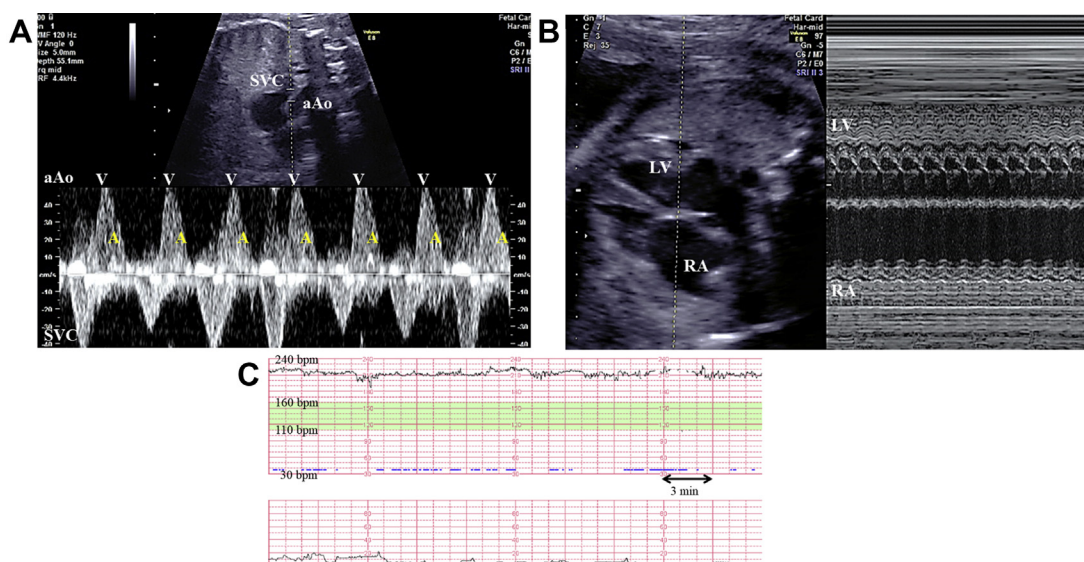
Supraventricular tachycardia (SVT). Sustained SVT was confirmed by Doppler and M-mode recordings at 30 weeks of gestation. A: Doppler recording of superior vena cava (SVC)–ascending aorta (aAo) flow showed short ventriculoatrial (VA) tachycardia (VA/atrioventricular [AV] ratio = 0.44) with a ventricular rate of 215 beats per minute (bpm). B: M-mode recording using a 4-chamber view showed 1:1 AV conduction with a ventricular rate of 215 bpm. C: Fetal baseline heart rate varied between 210 and 220 bpm on cardiotocography. A indicates the retrograde A wave in the SVC corresponding to atrial contraction. V indicates the aortic ejection wave (V wave). LV = left ventricle; RA = right atrium.
